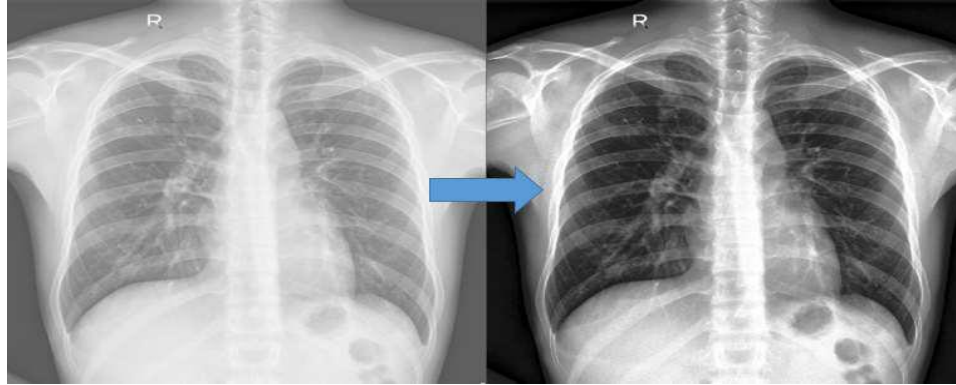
X-Ray Histogram Equalization
